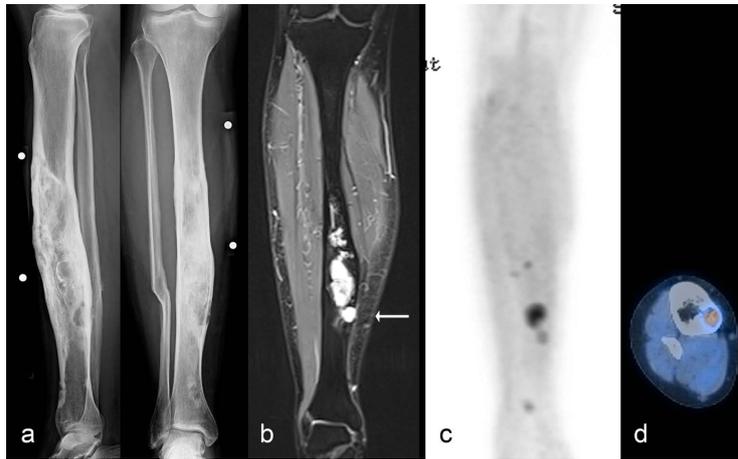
Synopsis of X-Ray (a), MRI (b) and FDG-PET-CT ((c) and (d)) in 2020 shows the metabolically active osteolysis (arrow) distal to the main changes, which was curetted and pathologically demonstrated to be Adamantinoma.
